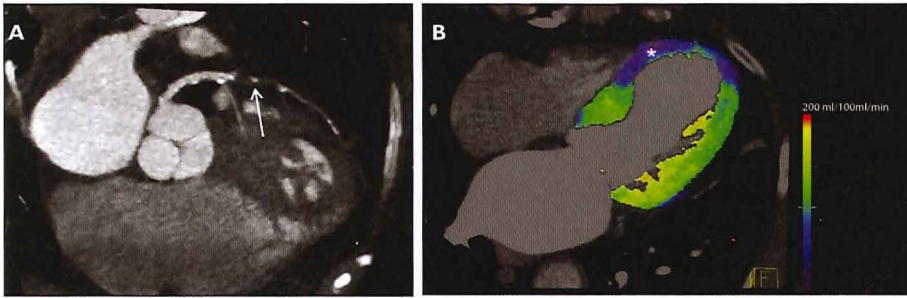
Images of a 75-year-old woman with typical chest pain. Curved multiplanar reformat of the left anterior descending (LAD) coronary artery shows a subtotal occlusion of the mid-LAD (arrow) (A). Stress myocardial CTP color-coded map in a 4-chamber view, from dynamic CT acquisition using a dual source CT scanner, shows a hypoperfused area at the level of the septum and the apex (*). Both myocardial areas look thinner compared to the other myocardial segments (B). MR delayed enhancement imaging in a 4-chamber view (T1 weighted-inversion recovery gradient echo sequence 20 minutes after infusion of gadolinium; TR: 6.3; TE: 1.5; flip angle 20°; inversion pulse of 180°; matrix 192 x 160) (C) shows a sub-endocardial hyperintensity (arrow) in the same myocardial territories revealing the presence of myocardial infarction.
